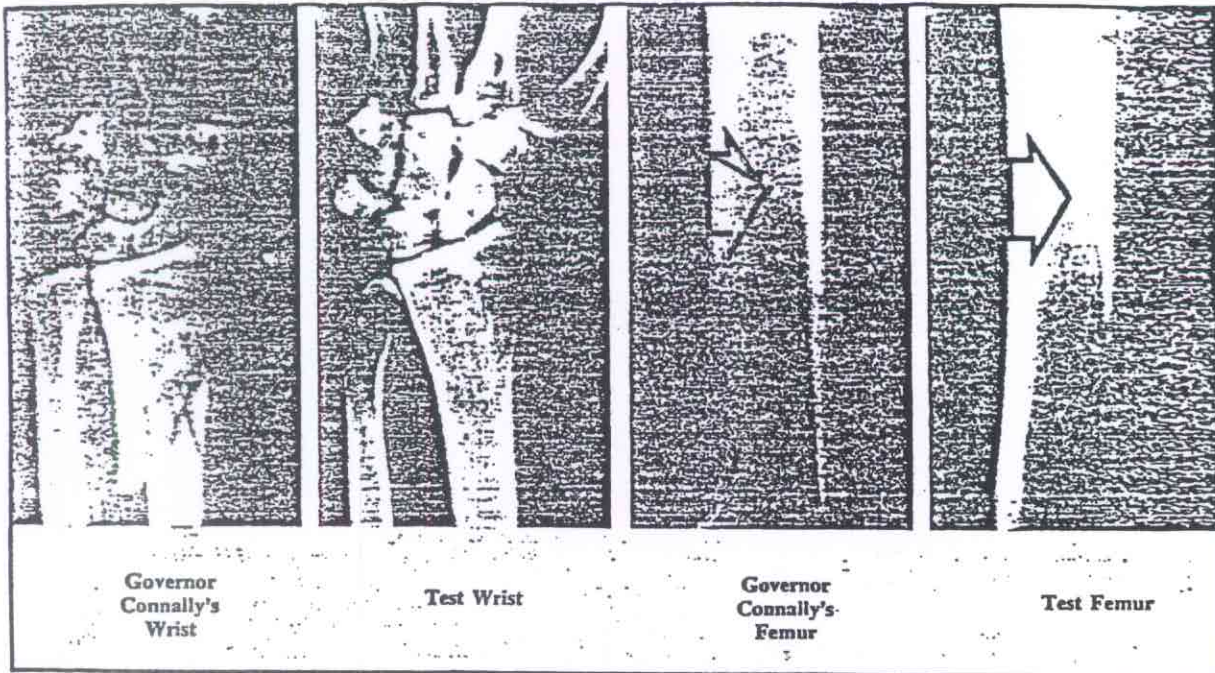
X-RAYS OF GOVERNOR CONNALLY: The x-rays of Governor Connally showed three fragments (of soft gray lead) in his wrist (left) and one in his femur. We believe these were scraped off the extruded lead core now projecting from the rear end of bullet 399 (see Figure 1) as it travelled almost
